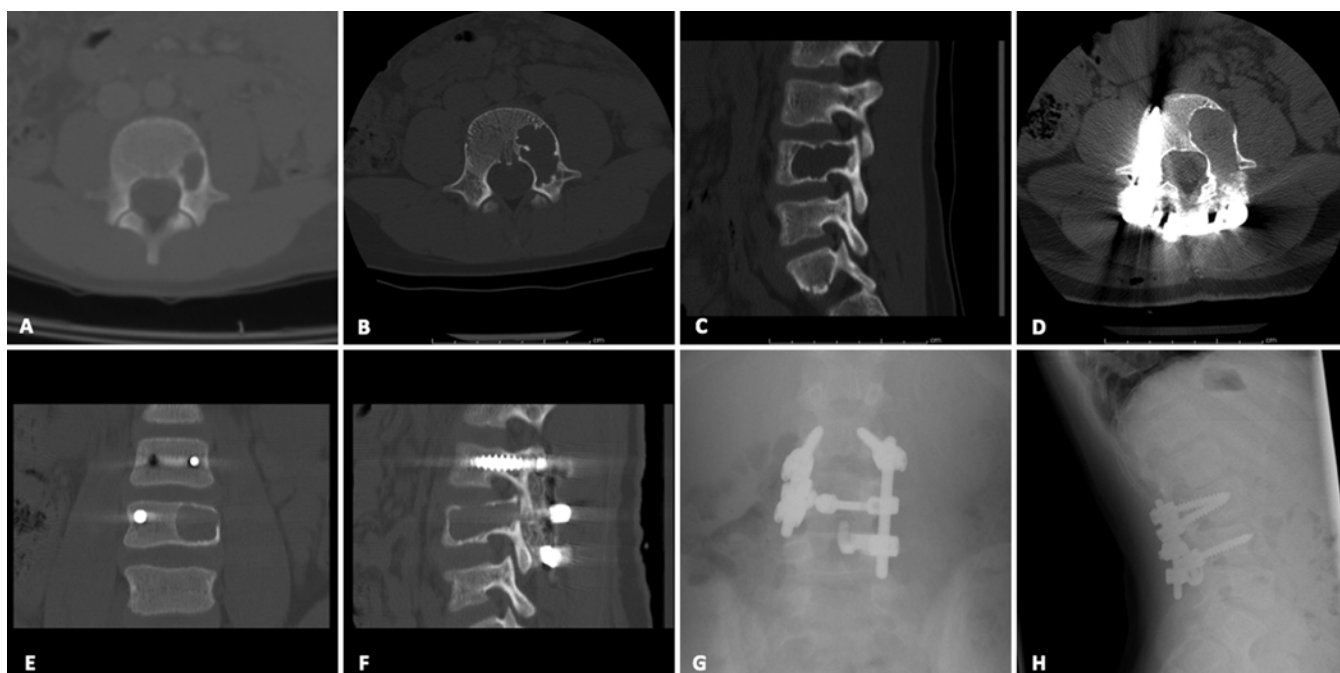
Case 3. Images obtained in a patient with L-4 posterior involvement. An initial axial CT scan (A) showing the ABC when it was incidentally found during an appendicitis workup. Repeat axial (B) and sagittal reconstruction (C) CT scans obtained 15 months after the initial scan original demonstrating progression of the disease. Postoperative axial (D), coronal reconstruction (E), and sagittal reconstruction (F) CT scans were obtained after curettage and L3–4 instrumented fusion. Anteroposterior (G) and lateral (H) plain radiographs of the lumbar spine obtained 2 years after surgery showing intact instrumentation.
